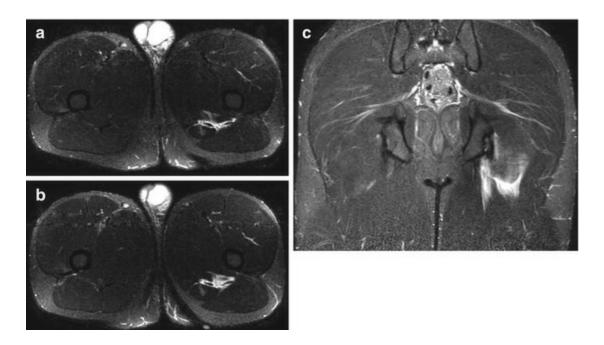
A 21-year-old male professional soccer player presenting with discomfort in the posterior thigh after a training session. Axial (a, b) and coronal (c) STIR MRI show edema in the proximal myotendinous junction of the semitendinosus, with little fluid in the intermuscular space but no muscle fiber disruption, consistent with a grade 1 injury
